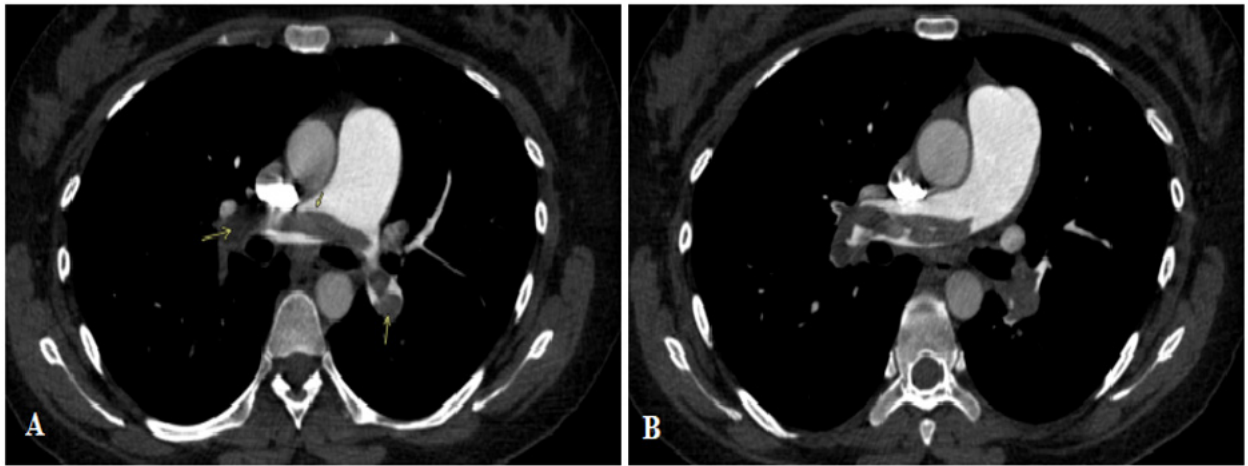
CT: A) Acute thrombus cast in the trunk of the pulmonary artery. B) Thrombus extending to bilateral lobar branches with complete occupation of its lumen.
